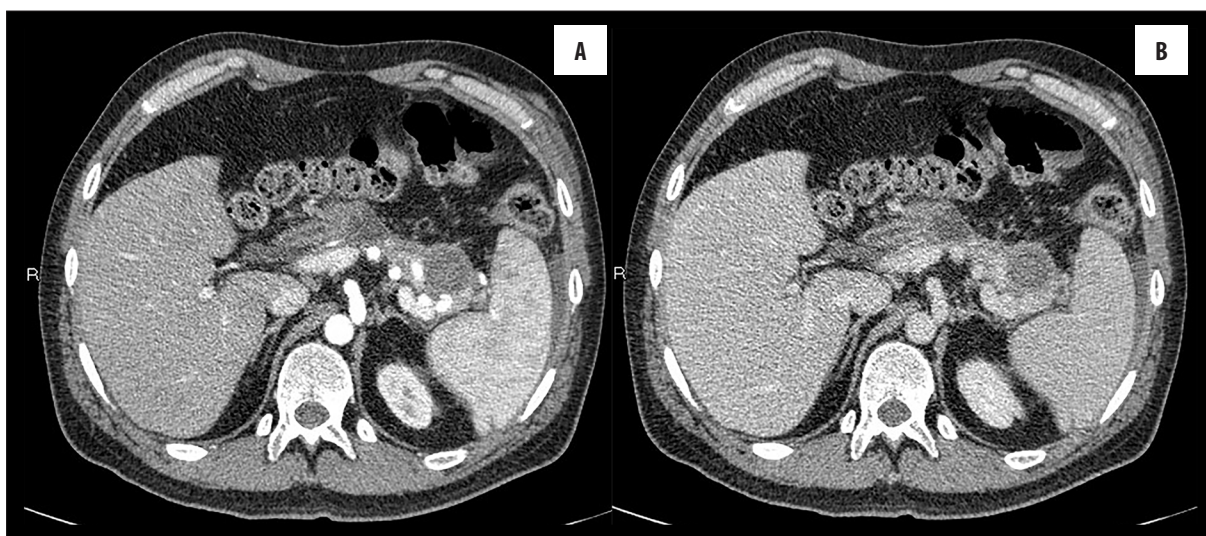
Contrast – enhanced CT scan performed immediately after thrombin injection shows a complete thrombosis of the pseudoaneurysm in both arterial (A) and portal (B) phases.
